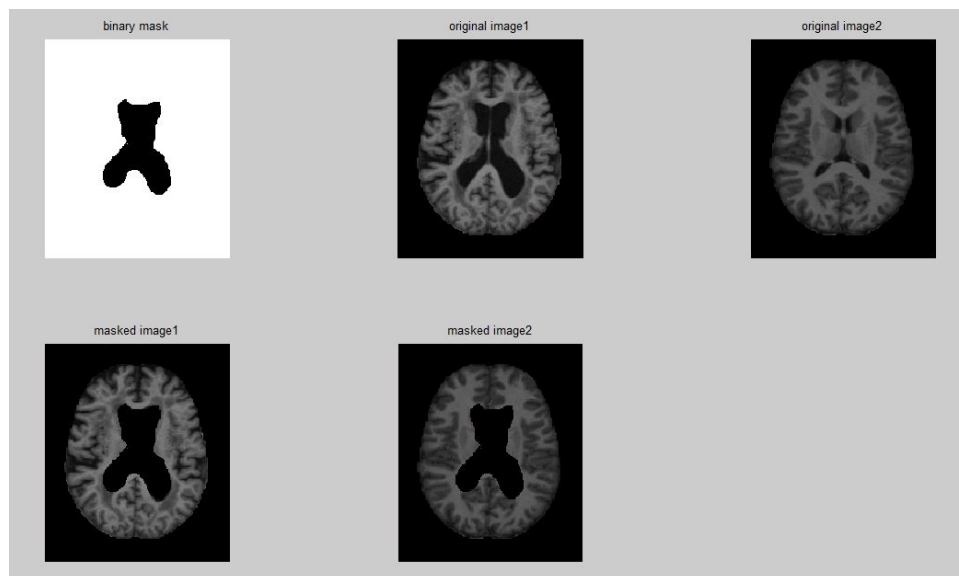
Masked image 1 and masked image 2 shows only outer part of MRI brain image.
